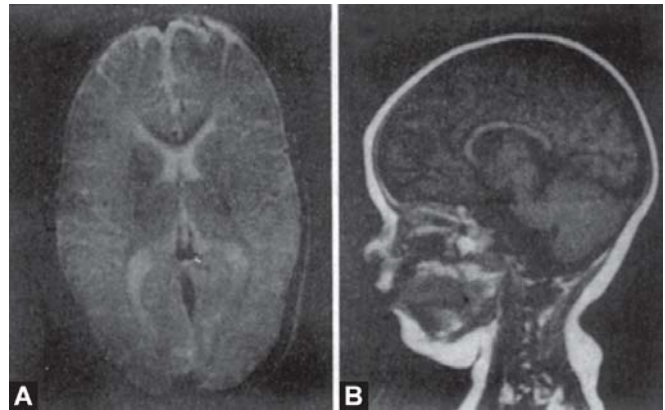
MRI of an 18-month-old. Picture on left shows a mild cerebral atrophy with little dilatation of the interhemisphere fissure, reduction of cerebral mass in frontotemporal region and in fissura Sylvii area. Picture on right shows hypodensity of centrum semi-ovale and rarefaction of the internal capsule (T2-weighted image)
